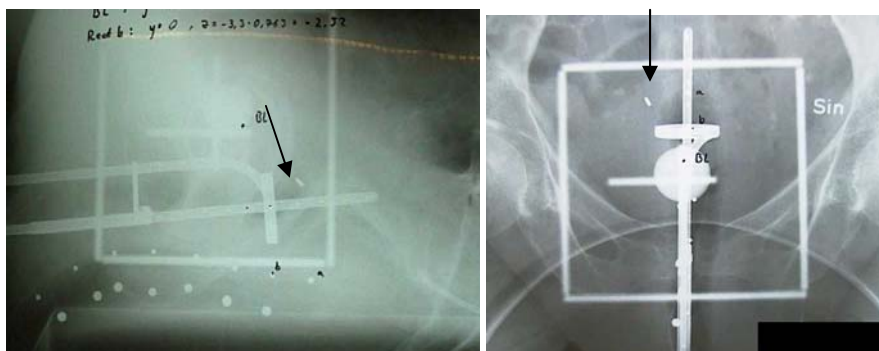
X-rays films, lateral and anterior views.
